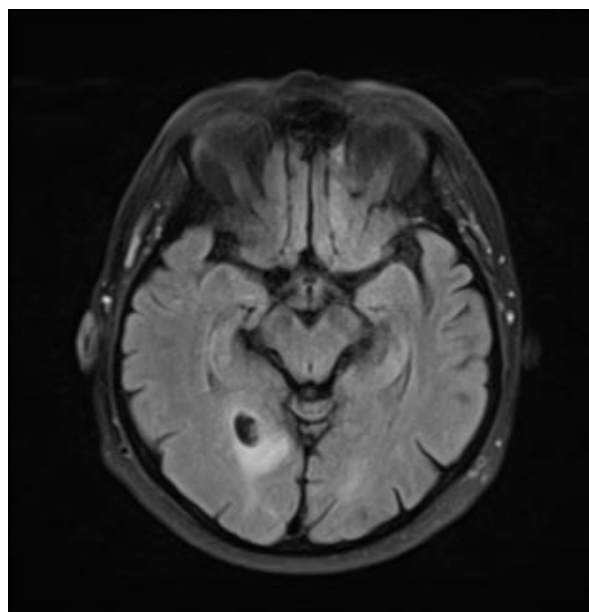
Typical cysticercus of *T. solium* in the right occipital lobe of the brain with visible scolex as an internal nodule in a cyst (hole-with-dot sign) surrounded by oedema. Magnetic resonance imaging (MRI). The authors' collection.
